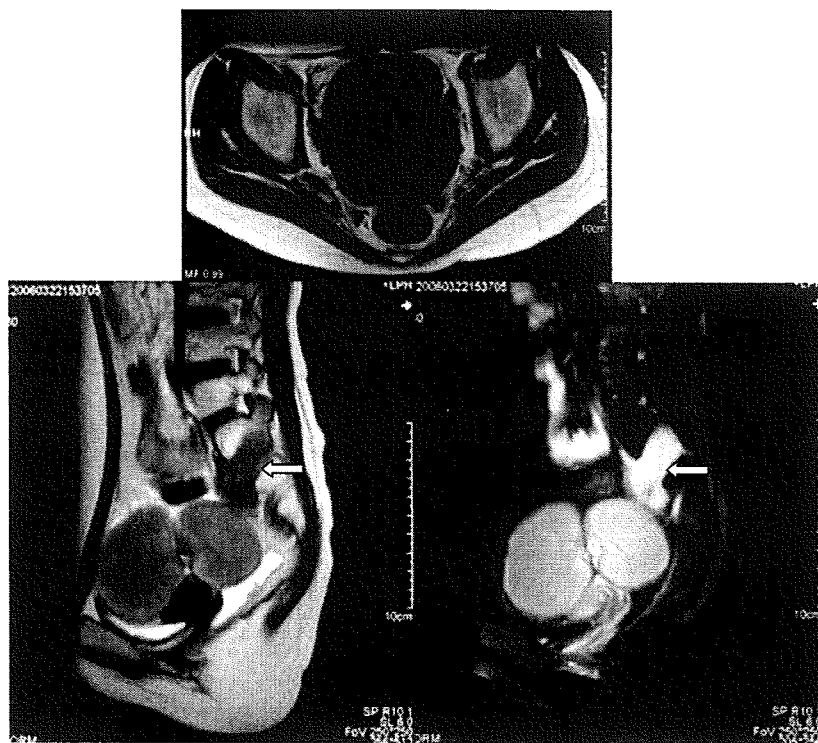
A magnetic resonance image showing pelvic masses. Top: T1-weighted axial image; left: T2-weighted sagittal image; and right: contrast-enhanced sagittal image. The sacral lesion, which was irradiated when the patient was 16, was one of the multiple recurrent lesions in the spinal cord (indicated by an arrow).
